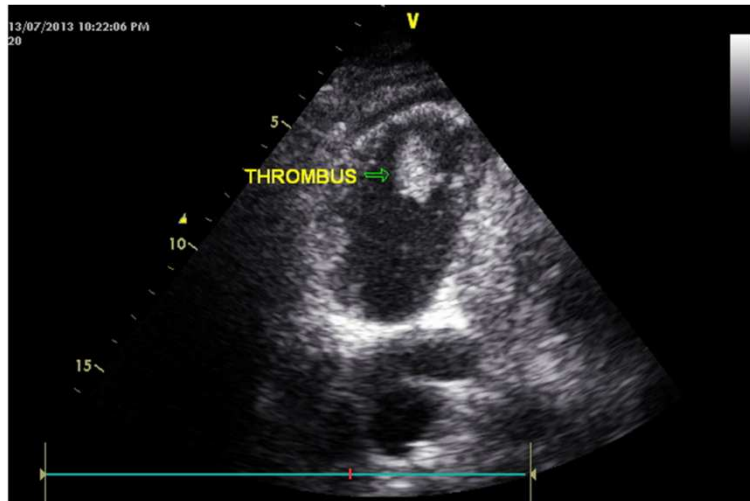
Trans-thoracic bedside echocardiography showing enlargement of right ventricle (RV) with fresh and freely mobile thrombus occupying the RV near the apex
